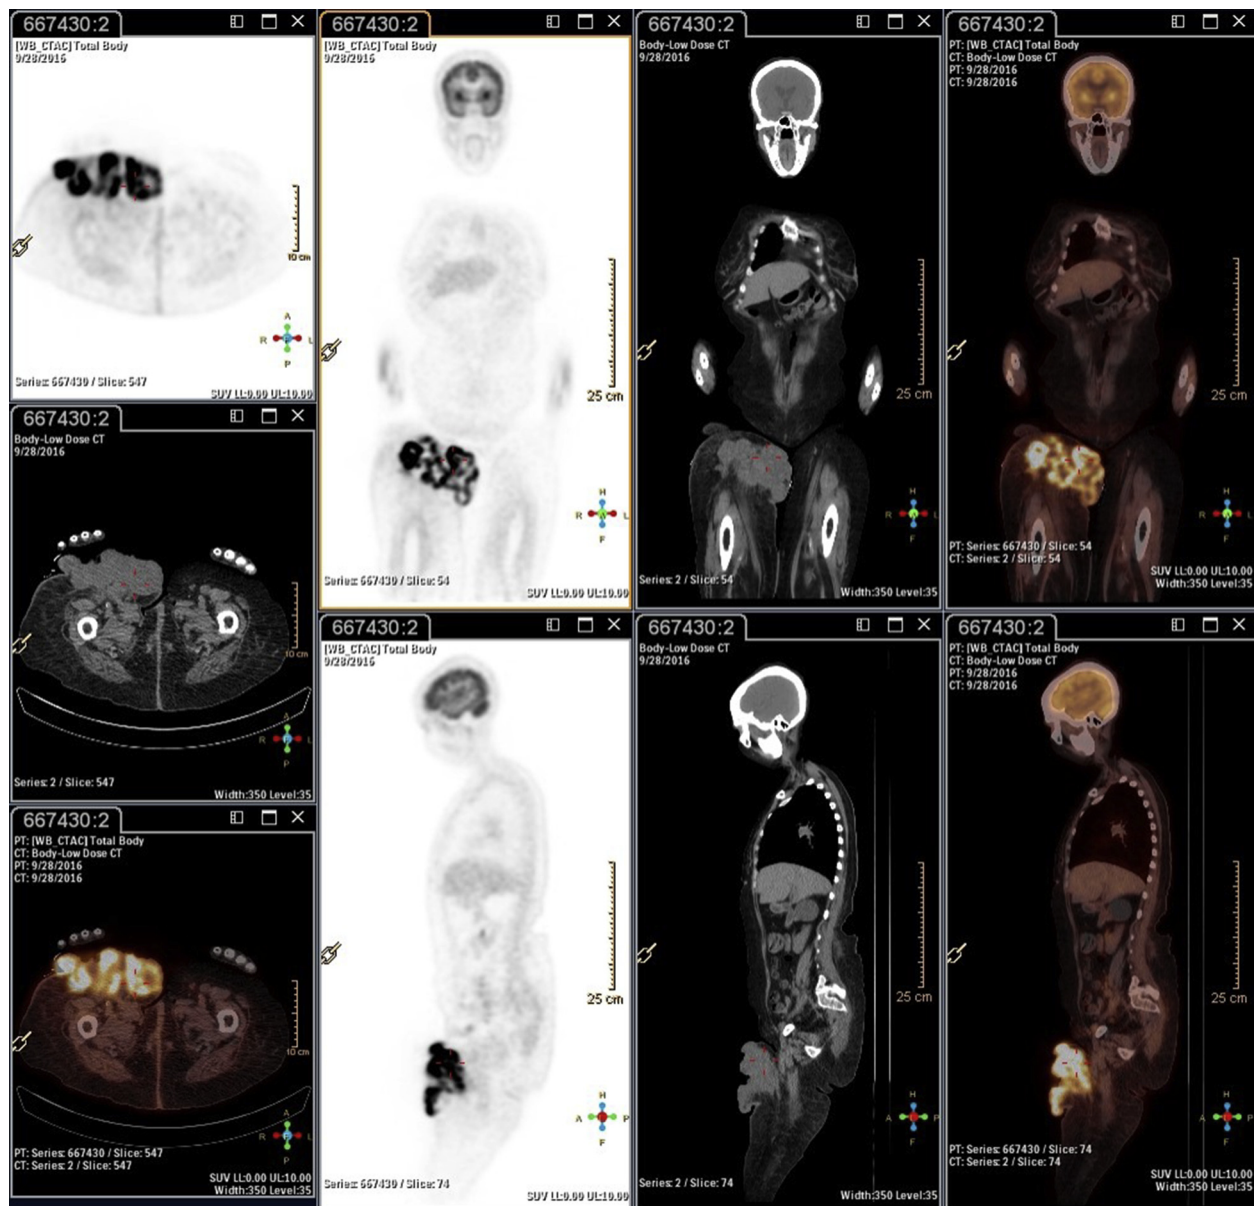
Staging positron emission tomography–computed tomography (left column, transaxial; top row, coronal; bottom row, sagittal) reveals mild uptake of fluorodeoxyglucose in the right heel mass and intense heterogeneous uptake of fluorodeoxyglucose in the right thigh mass. Also note the moderate uptake in multiple pathological lymph nodes.
